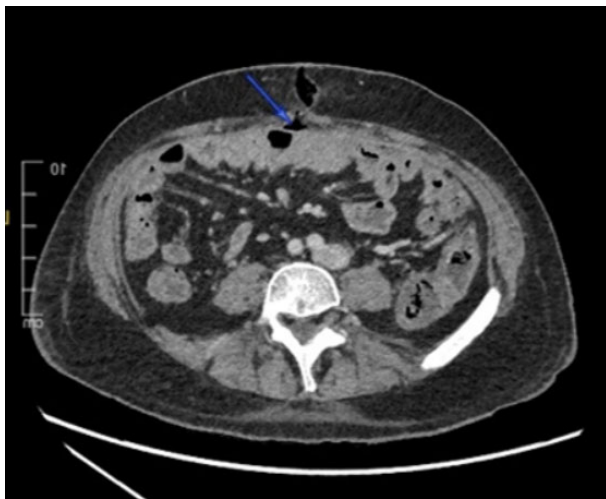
CT of the abdomen showing fistula track.
